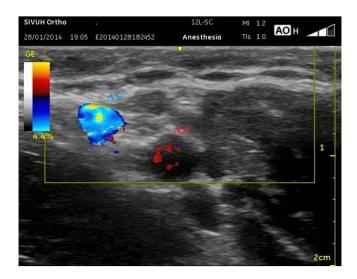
Ultrasound guided axillary brachial plexus block. Out-of-plane approach of the needle with respect to probe.
